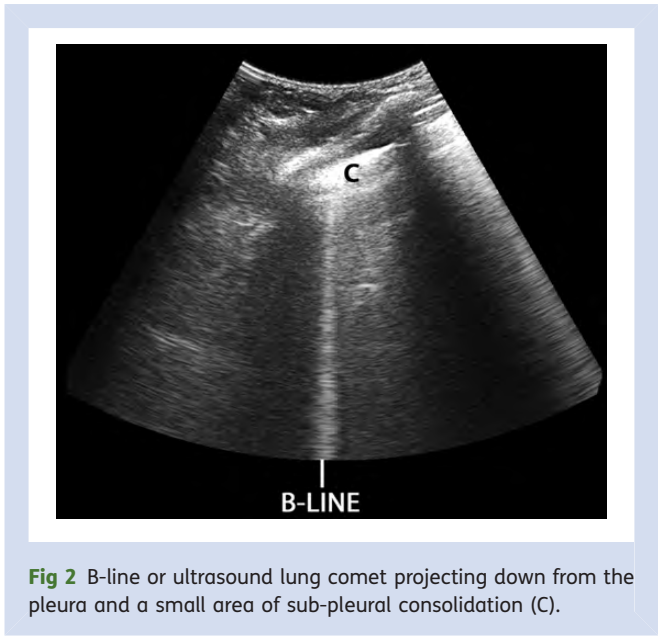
B-line or ultrasound lung comet projecting down from the pleura and a small area of sub-pleural consolidation (C).
